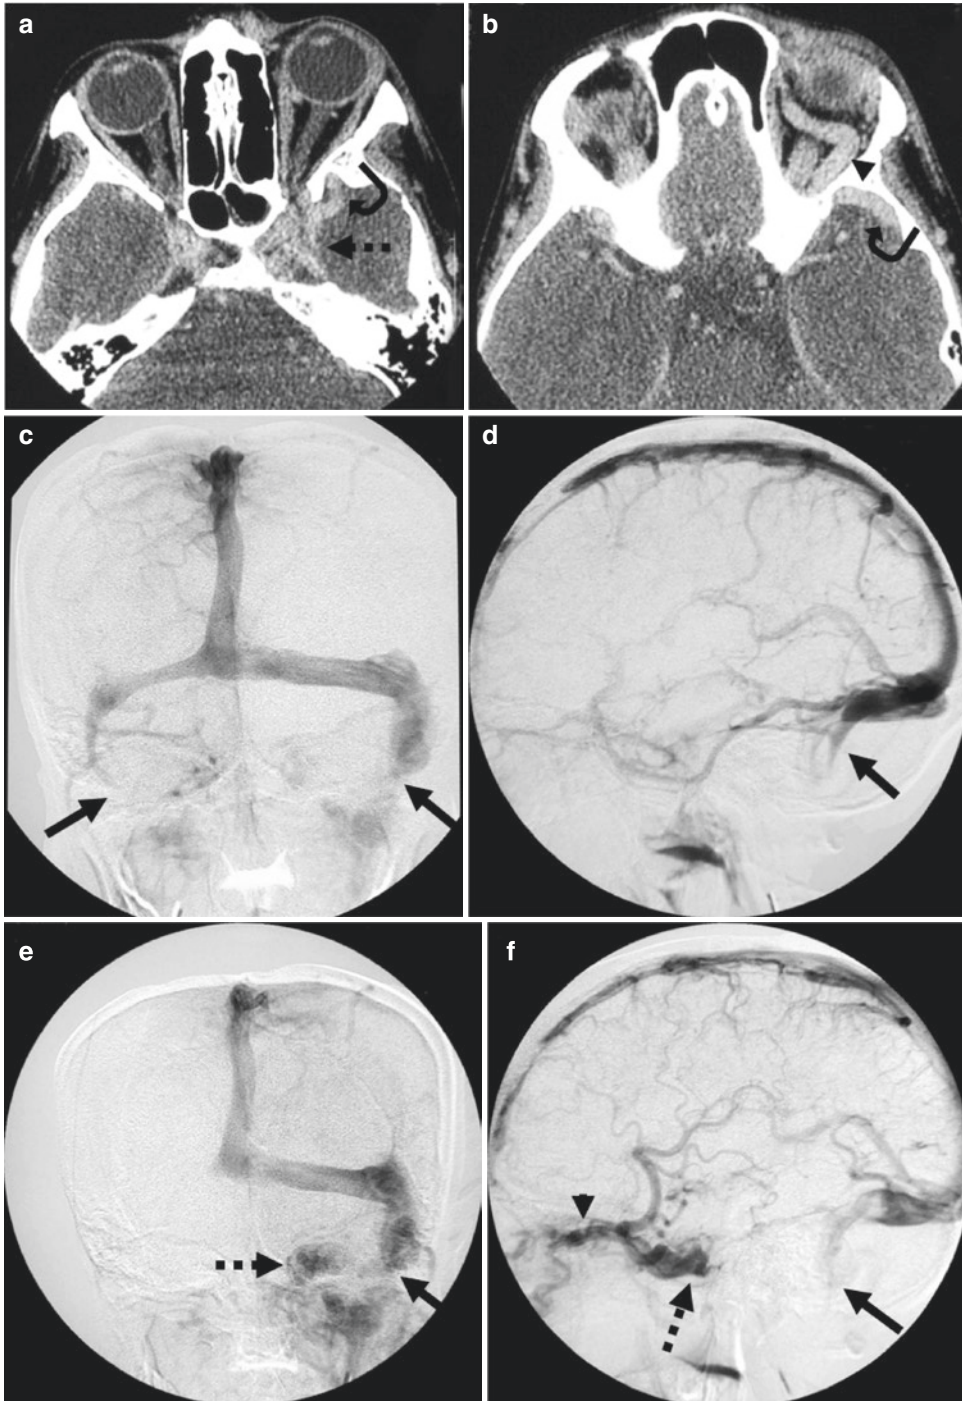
Congenital jugular stenosis with rerouting of drainage pathway via the SOV. (a, b) Axial contrast CT scan of a 7-year-old girl who presented with mild proptosis and compressible mass at the medial canthus of the left eye, no chemosis, no limitation of eye movement, no history of trauma, revealing enlarged left cavernous sinus (dashed
